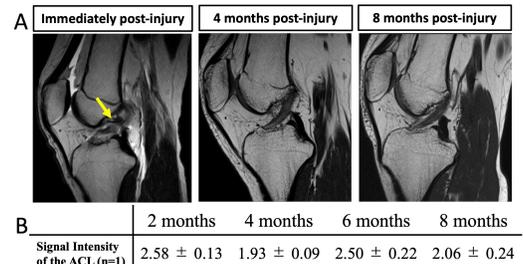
(A) Representative MRI image of the ACL healing process. (B) Signal intensity time series data of the ACL.
